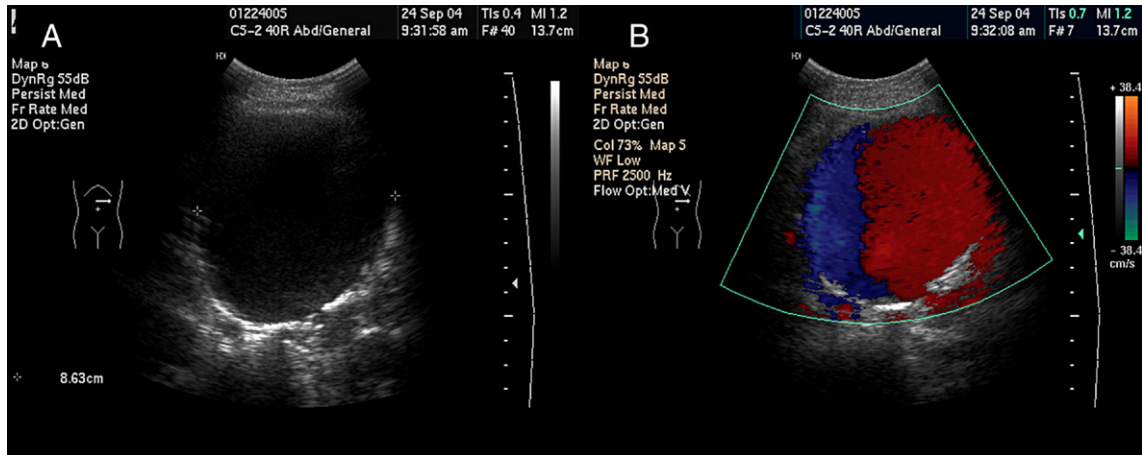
Abdominal color Doppler sonography. A: A huge anechoic cystic mass lesion in left upper abdomen. B: Color Doppler shows turbulent jet flow in cystic lesion.
